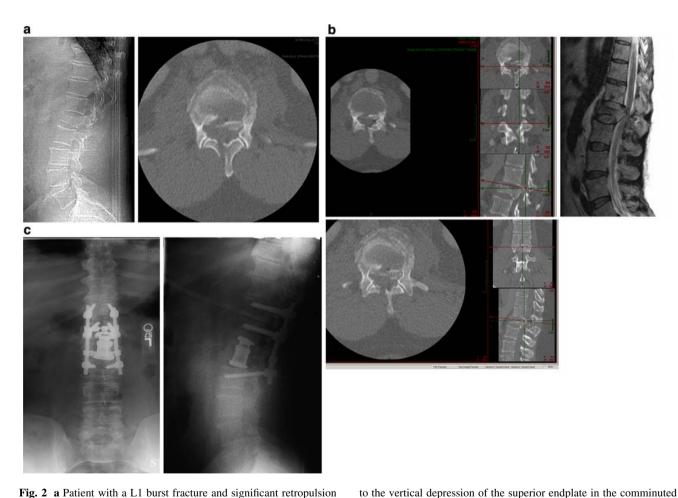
a Patient with a L1 burst fracture and significant retropulsion of the posterior wall in the spine canal. The patient is neurologically intact. The axial CT cuts (at the pedicle level) show a retropulsed fragment with what appears to be a dense area of cortex sitting anteriorly. This is initially thought to represents a reverse cortical sign with the fragment of the posterior wall flipped 180° with the cortex sitting anteriorly and the cancellous portion posteriorly (A3 type burst fracture). b Further scrutiny of contiguous axial views, the sagittal reconstruction and the MRI demonstrate that the posterior wall fragment (that we thought was flipped) correspond as a matter of fact
